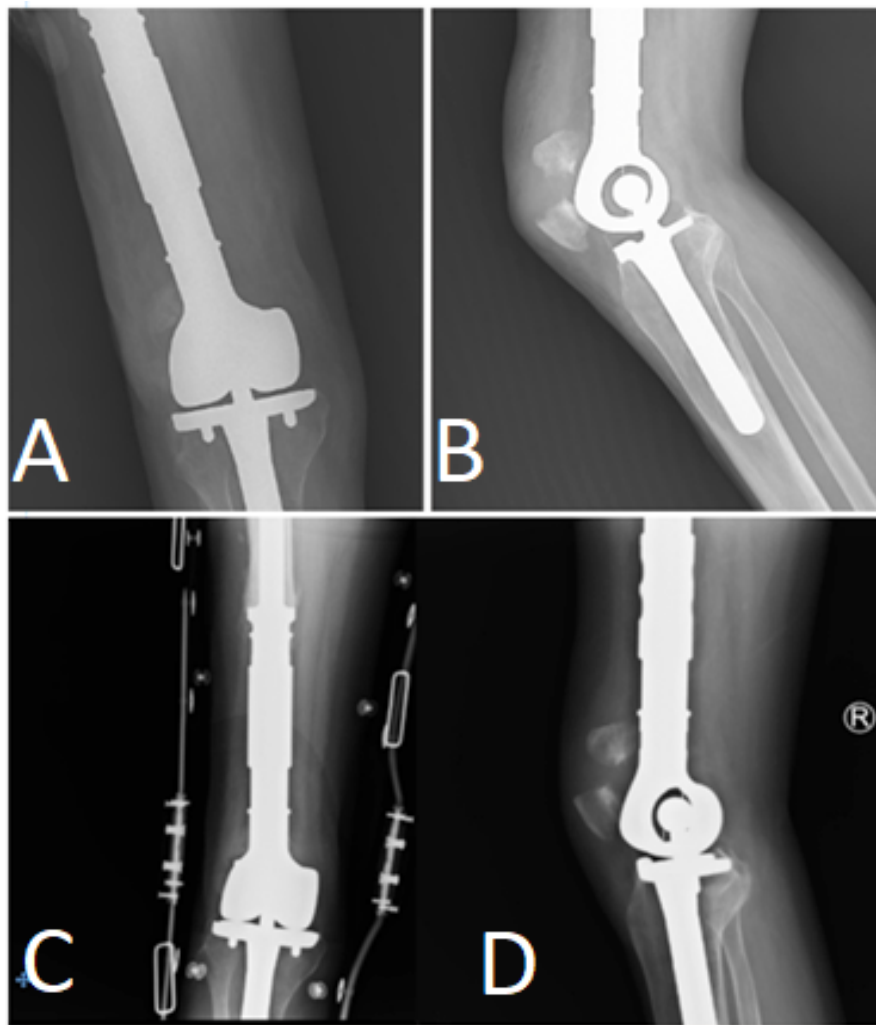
A and B) AP and lateral radiography after injury, C and D) Radiography after six weeks follow-up
